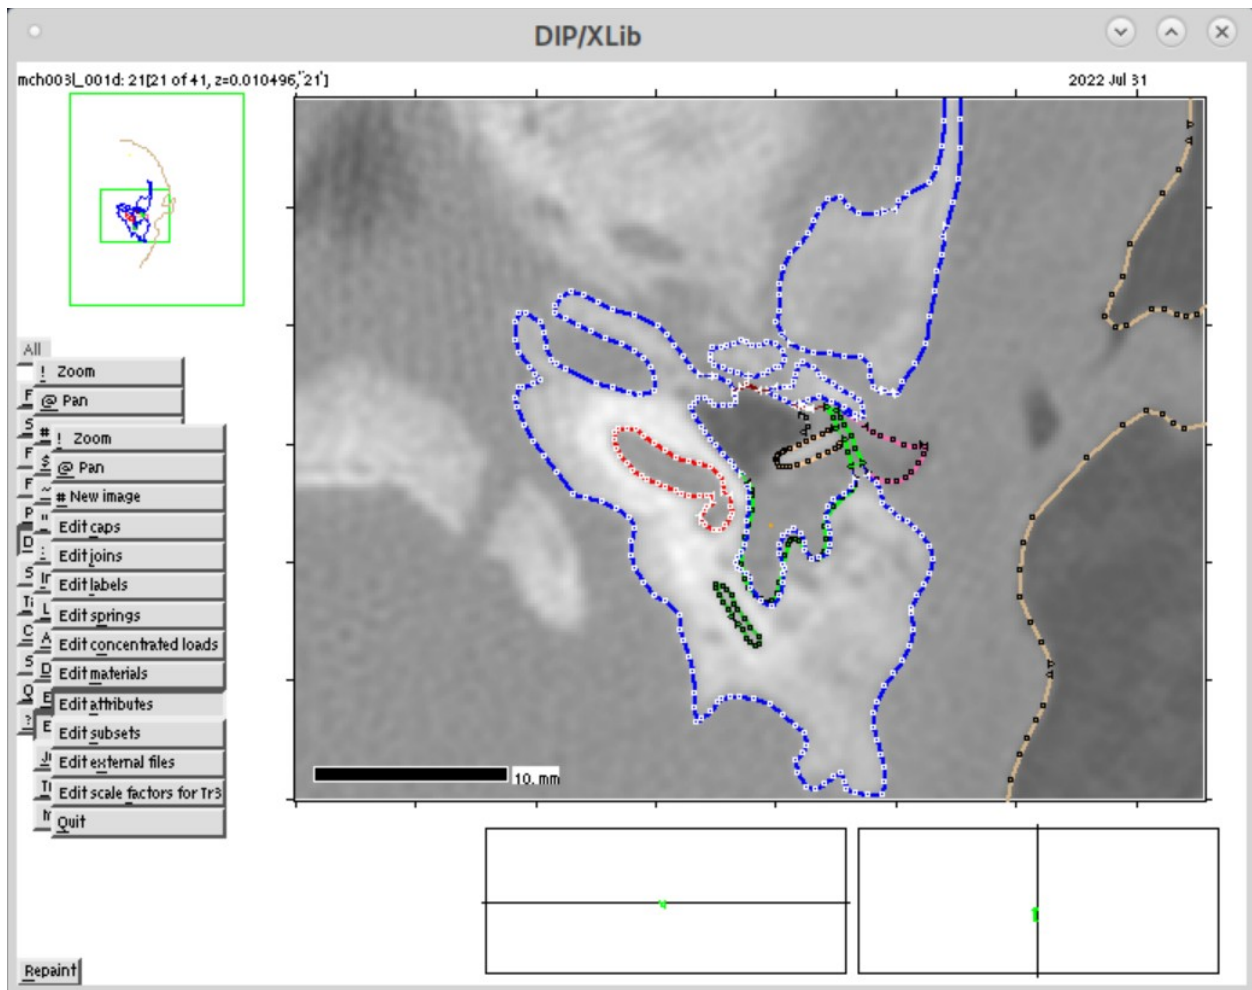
Fie (<http://audilab.bme.mcgill.ca/sw/fie.html>) graphical user interface used for segmentation of CT images.
